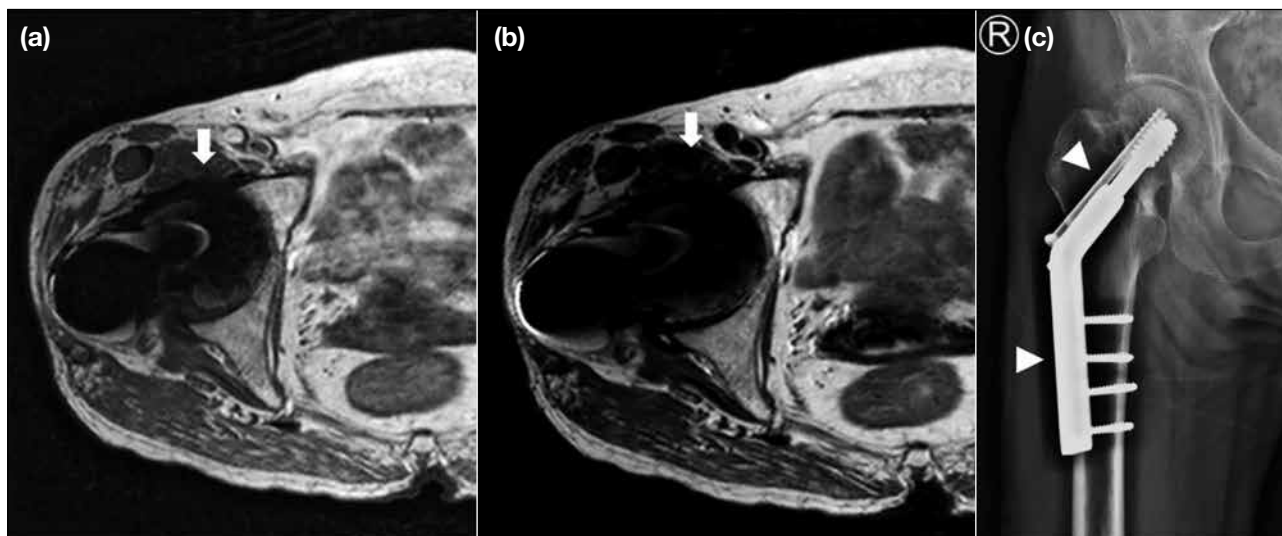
(a and b) Axial T1-weighted and T2-weighted fast spin echo images of the right hip at 1.5T magnetic resonance imaging showing significant susceptibility artifact (white arrows) due to the presence of metallic screw at the proximal right femur. (c) Radiograph of right hip showing the presence of metallic screw at the proximal right femur (white arrowheads).
